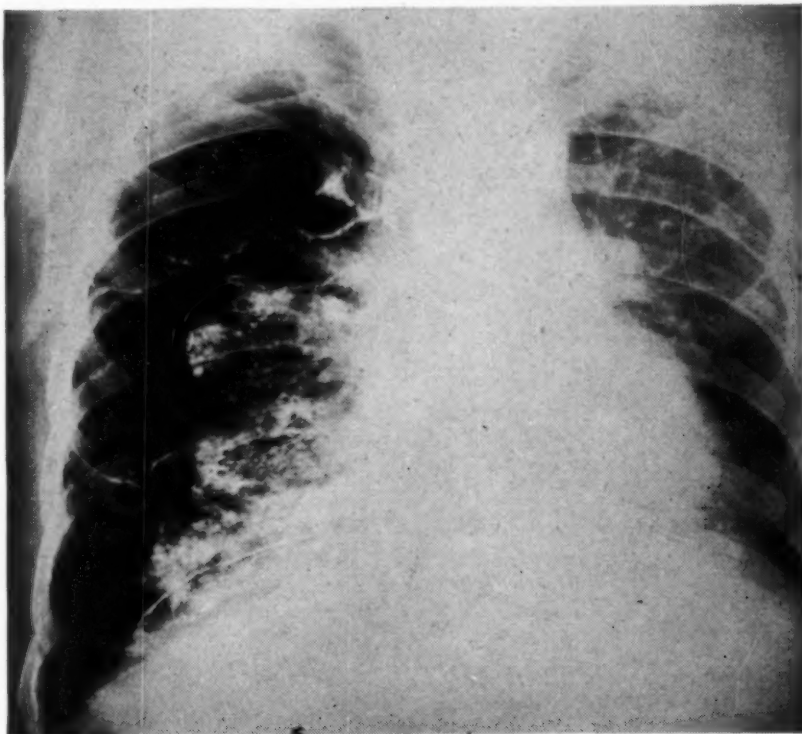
A. P. x-ray of chest in prone position following injection of iodized oil into the pleural space. The walls of the cyst are now clearly seen and it is evident that there are two separate spaces—cystic and pleural.
